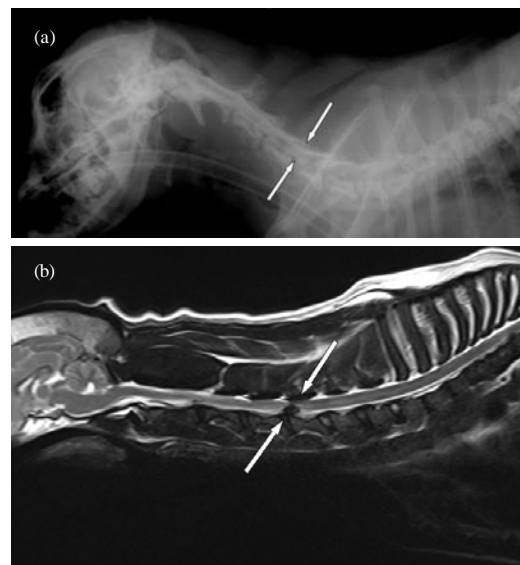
a) Myelographic view of intervertebral disc hernia (the contrast agent had not moved caudally from C4-C5 space) and b) MRI view of intervertebral disc hernia
